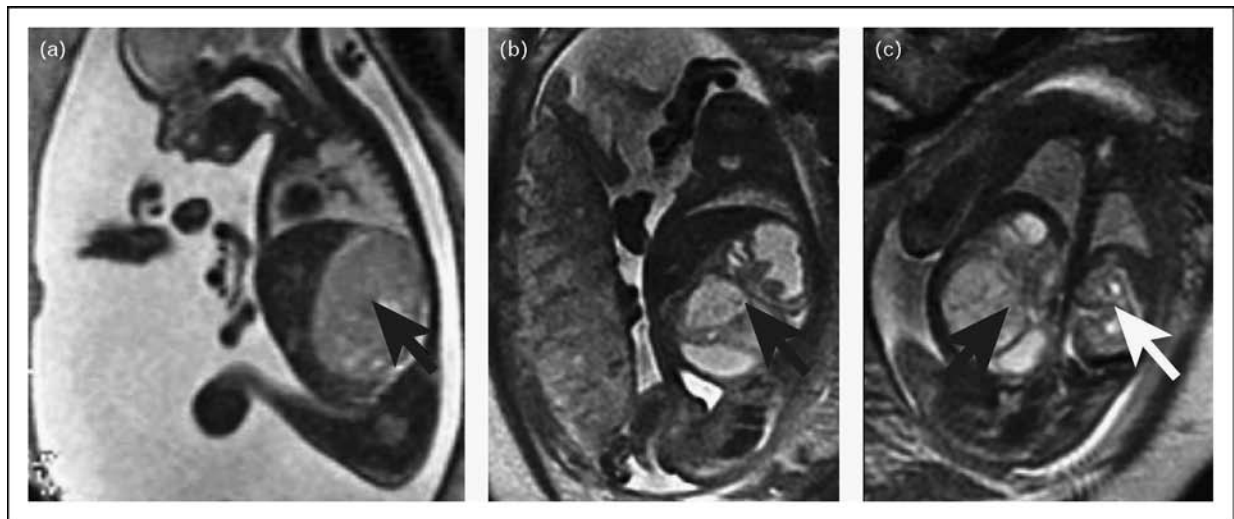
(a) Fetal MRI image showing a well-defined, homogeneously solid mass arising from the right kidney (black arrow). There was preservation of normal right renal tissue, and collecting system was noted posteriorly and inferiorly, which is consistent with the diagnosis of congenital mesoblastic nephroma. (b,c) Fetal MRI images demonstrating axial (b) and coronal (c) sections through the fetus showing a complex right renal mass (black arrow) with a dilated upper-pole collecting system with low signal mass extending into the collecting system. There is a lobulated heterogeneous high signal mass in the lower pole. There is no involvement of the contralateral kidney (white arrow) and the mass compresses the adjacent liver, but is separate. These findings are consistent with a Wilms' tumor.
